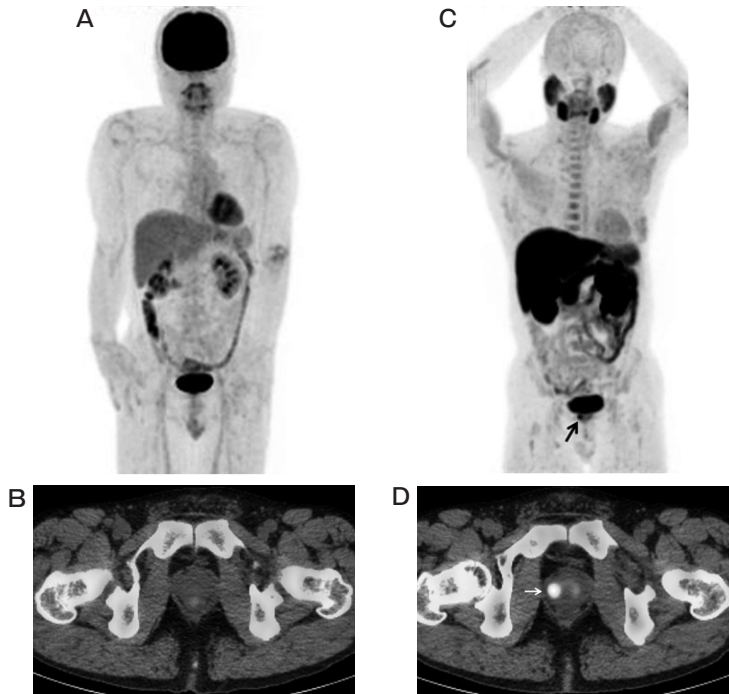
Representative case of a 50-year-old man with prostate cancer (Gleason score 4+3) and PSA level 15.76 ng/mL. A, Maximum intensity projection (MIP) from FDG-PET showing no abnormal findings; B, FDG-PET/CT image showing no abnormal findings at the same level as panel D below; C, MIP from ^{11}C -choline PET showing abnormal ^{11}C -choline uptake in the right side of the prostate gland (*arrow*); D, ^{11}C -choline PET/CT image showing moderate ^{11}C -choline uptake (SUVmax 5.22) in the right side of the prostate (*arrow*), reflecting primary prostate cancer.
